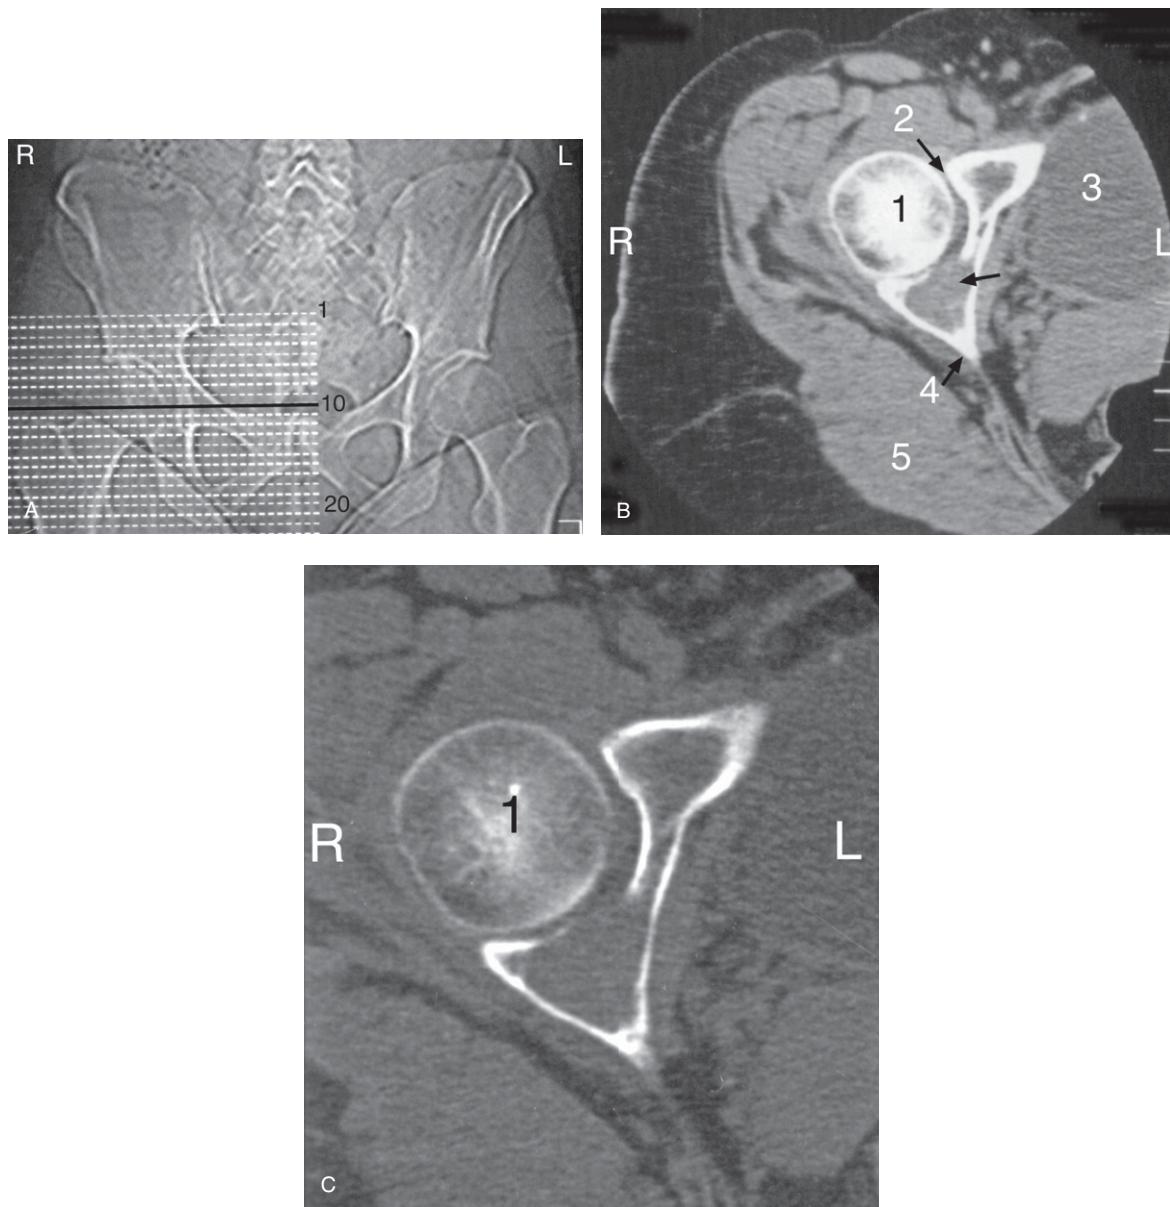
CT scout view (A) and axial images of the right hip (B = soft tissue window and C = bone window) at the level of the solid line (10) on the scout film. The axial images show part of the bony metastasis (arrow) producing a lytic defect with articular surface destruction in the right posterior acetabulum. 1 = head of femur; 2 = acetabulum; 3 = urinary bladder; 4 = ischial spine; 5 = gluteus maximus muscle; R = right side of patient.
